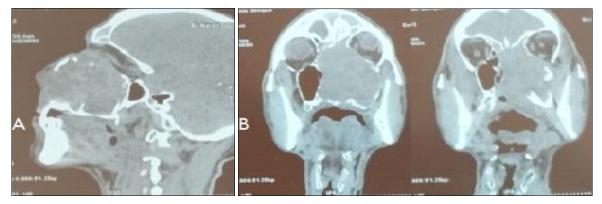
Facial CT scan: A: Sagittal section showing the locally advanced mass. B: Frontal section showing the mass
